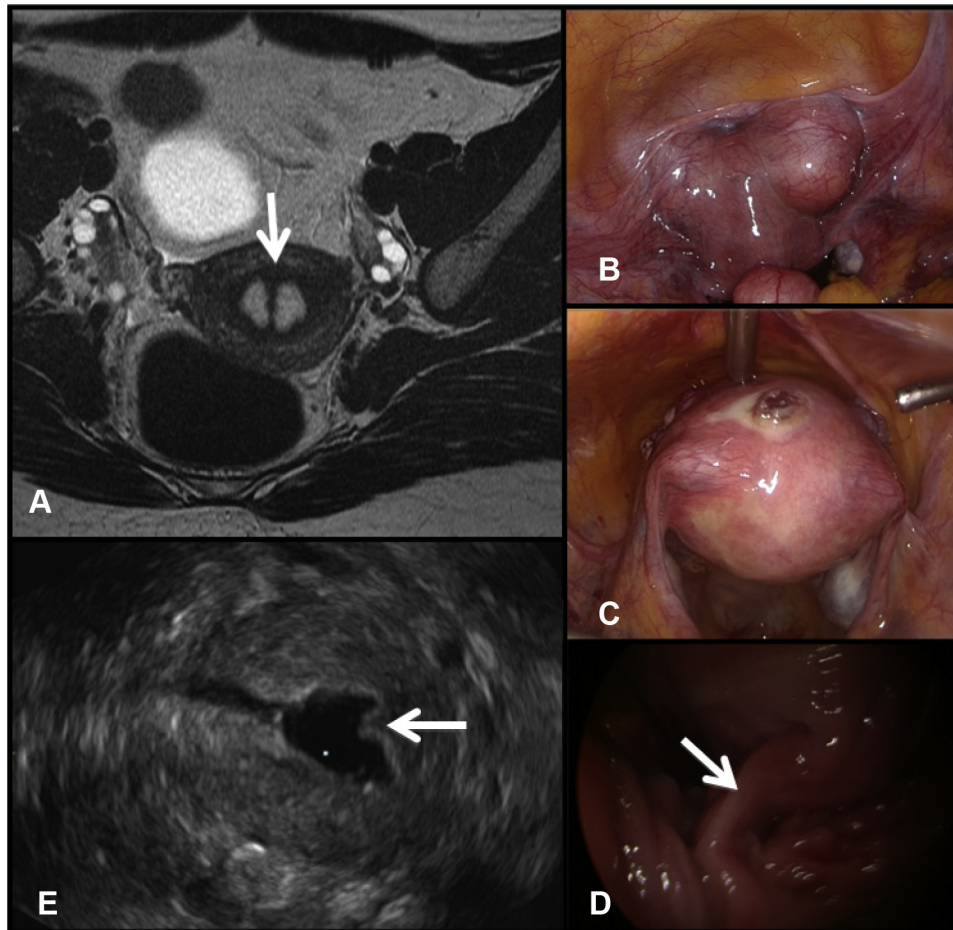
Images of Patient B. (A) Axial T2-weighted magnetic resonance imaging pelvis image showing a septate uterus. (B) Laparoscopic view of the pelvis showing multiple fibroids. (C) Laparoscopic view of the pelvis after myomectomies showing a normal uterine fundus. (D) Upper vaginal septum. (E) Three-dimensional sonographic image showing a small residual septum 3 months after resection.
